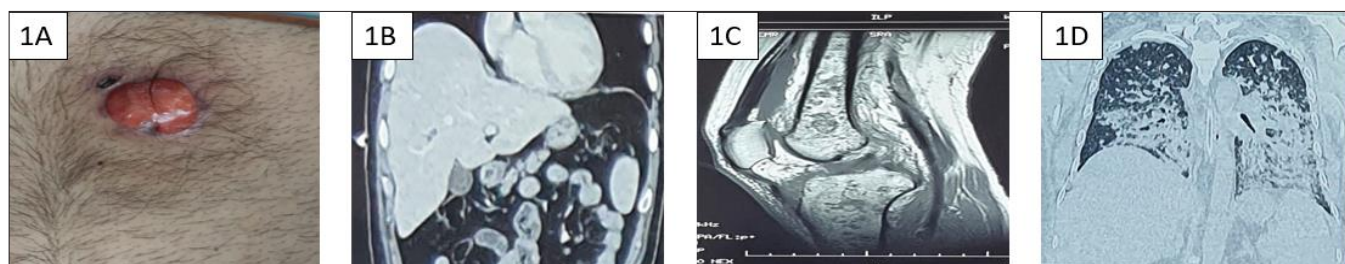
A. Ulcerated wound on anterior abdomen. B. Non-contrast computed tomography showing multiple liver abscess. C. Magnetic resonance imaging of right knee joint showing osteomyelitis of tibia, femur and synovial fluid collection. D. High-resolution computed tomography showing multiple conglomerate nodules in bilateral lung fields.
